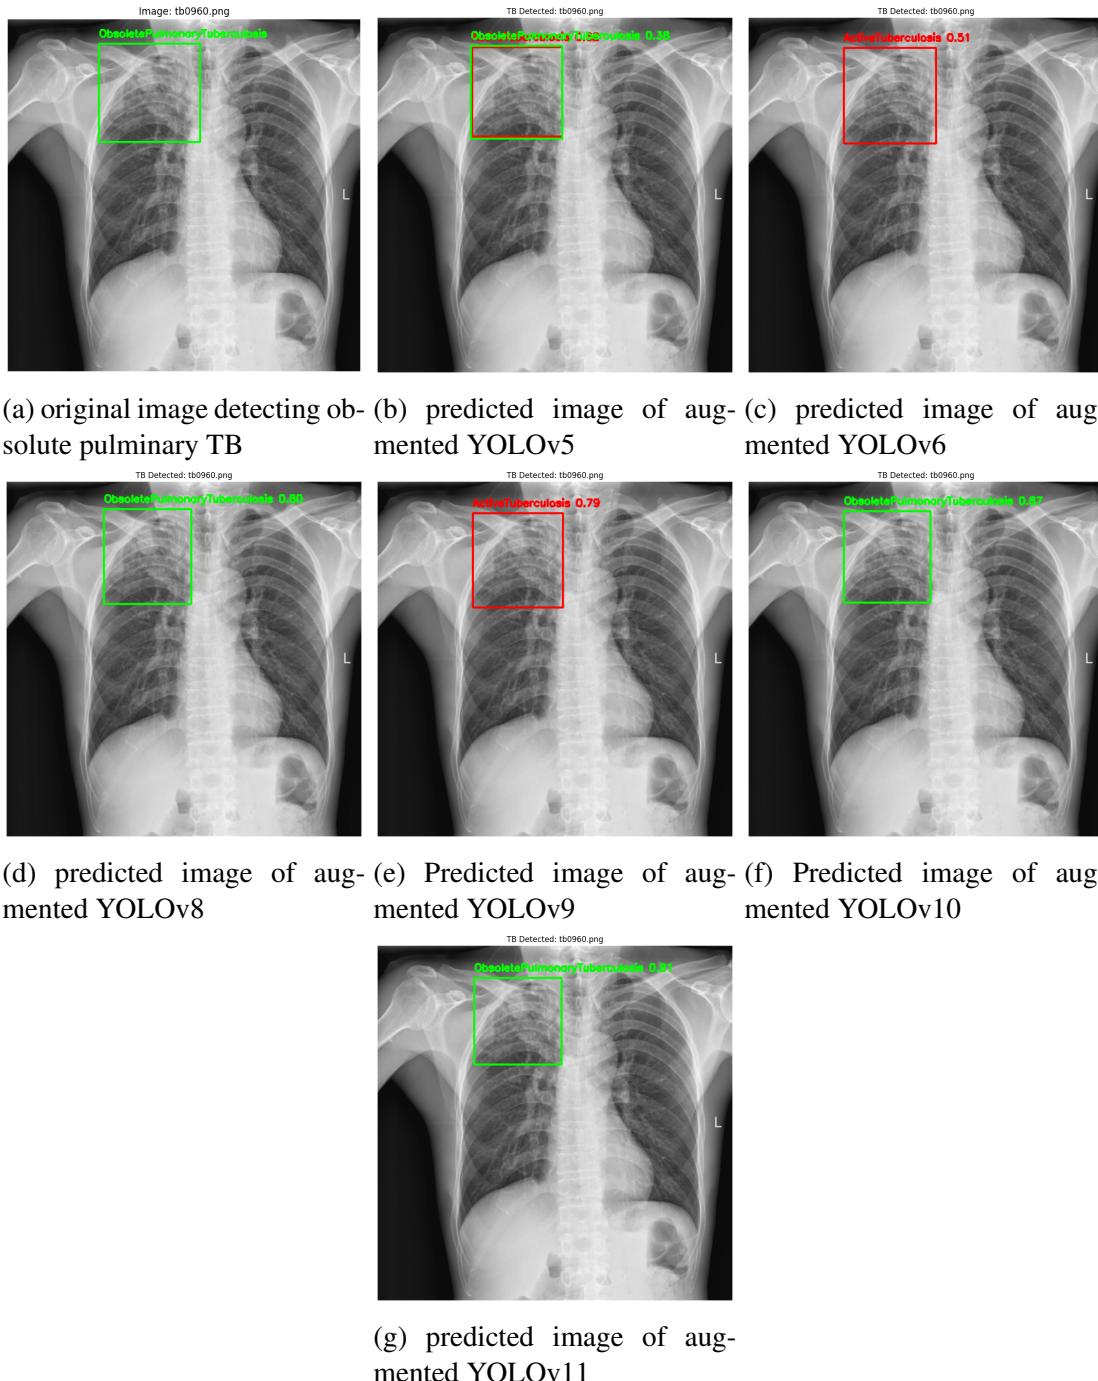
Comparison of original x-ray of absolute pulmonary TB with different augmented yolo models
